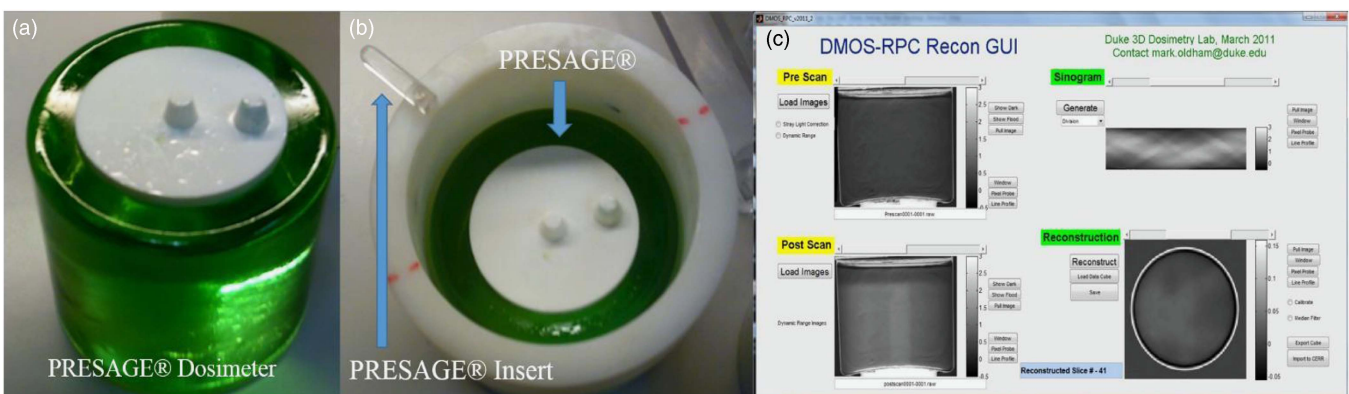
(a) PRESAGE[®] dosimeter and (b) PRESAGE[®] insert containing plastic insert and PRESAGE[®]. (c) Duke Midsized Optical-CT Scanner (DMOS) reconstruction graphical user interfaces.
